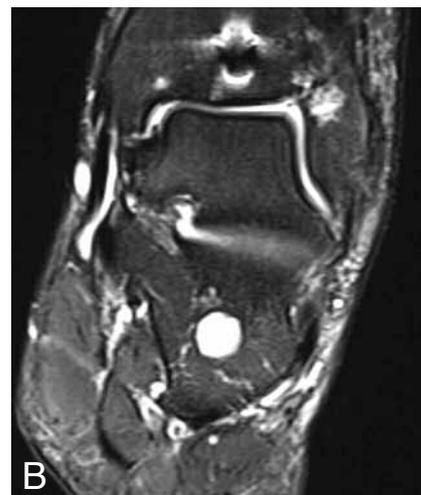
MRI of the left ankle.
